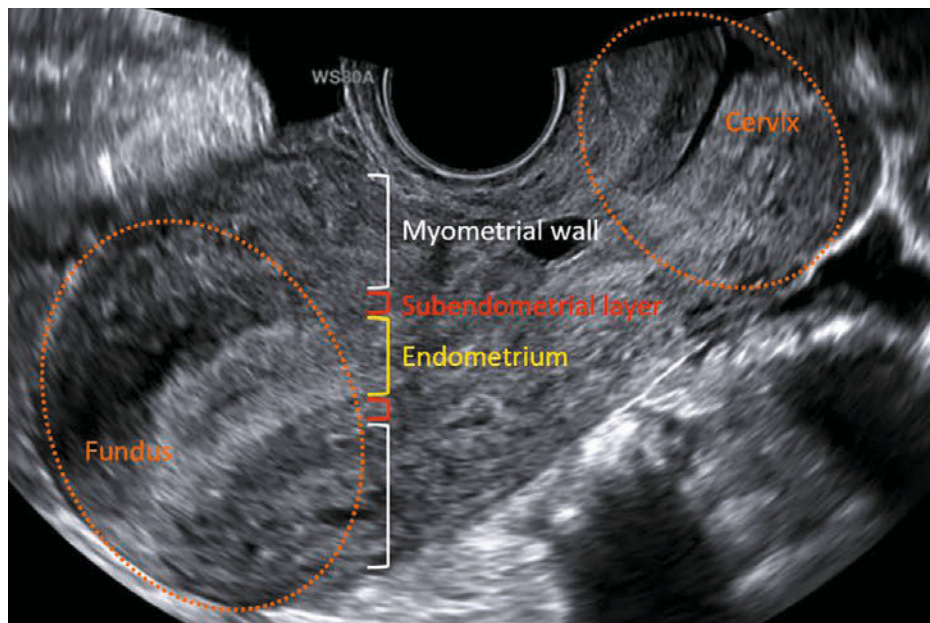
Transvaginal ultrasound of the uterus, presenting the subendometrial layer (in red)
